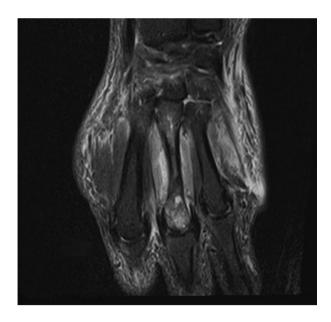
MRI demonstrating osteomyelitis of the third metacarpal bone.
